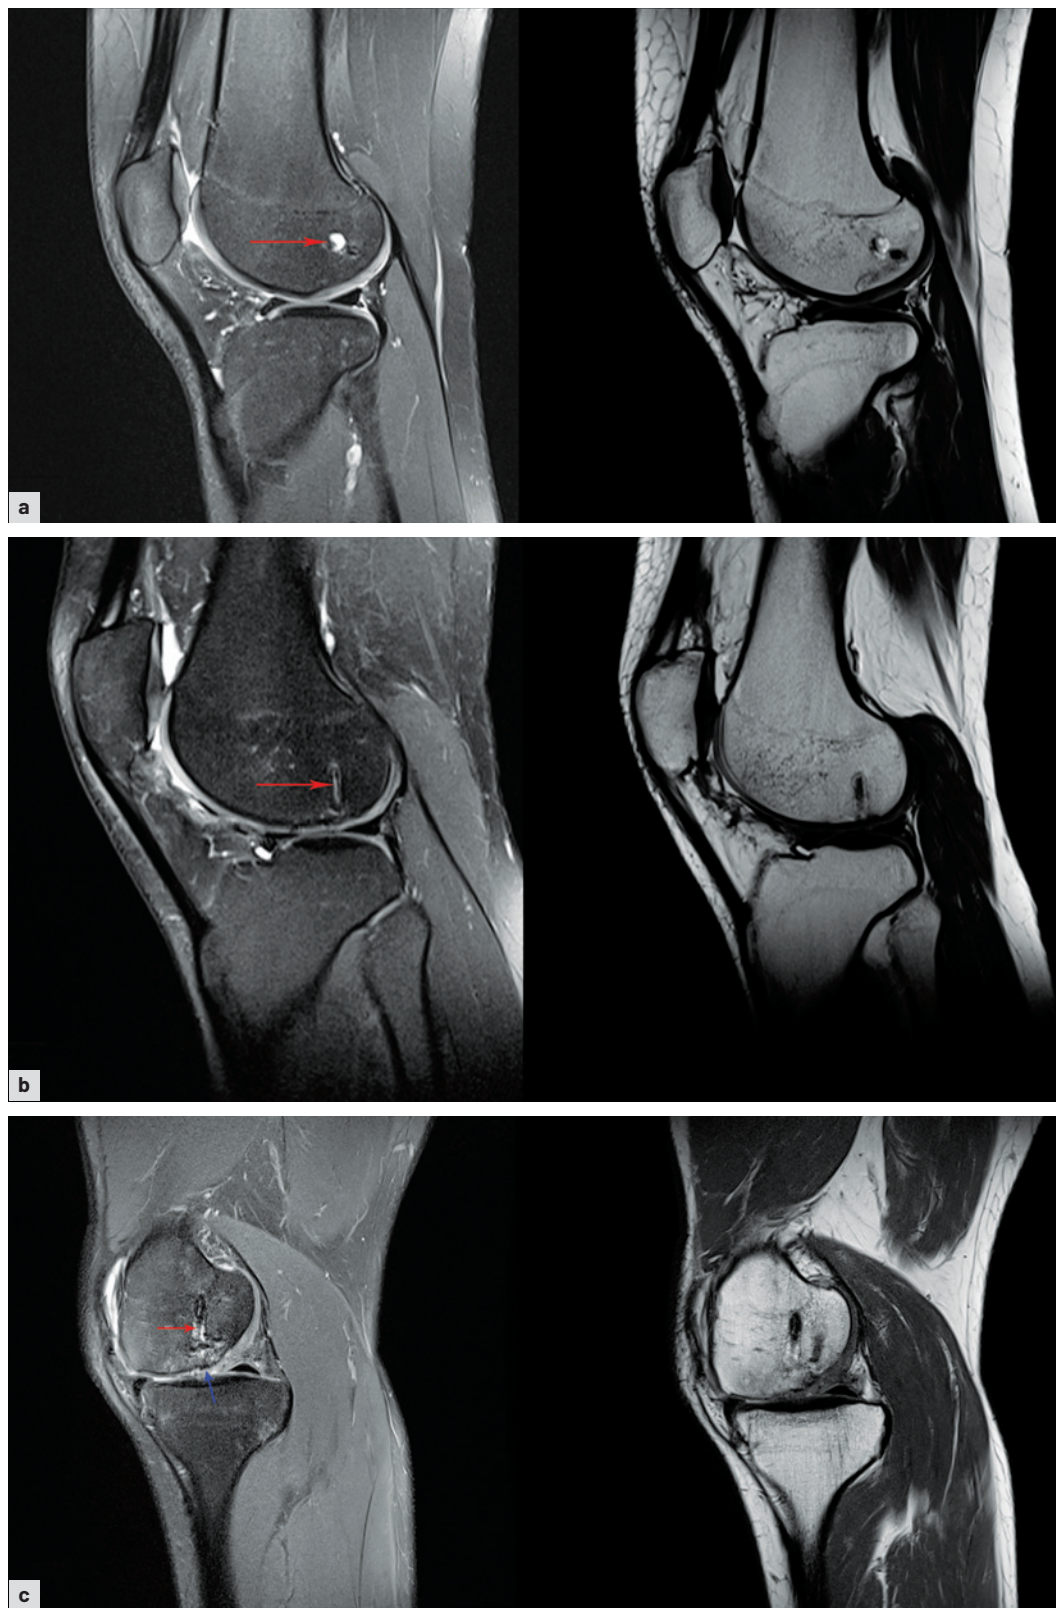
Fluid collection and formation of linear hyperintensities on MRI in individual patients. Localized fluid collection in the area of the original screw site (red arrow) (a). Linear hyperintensity in the area of the original screw site (red arrow) (b). Fluid collection is adjacent to the zone of the original screw (red arrow), and extensive chondro-pathy is noted (blue arrow) (c).
